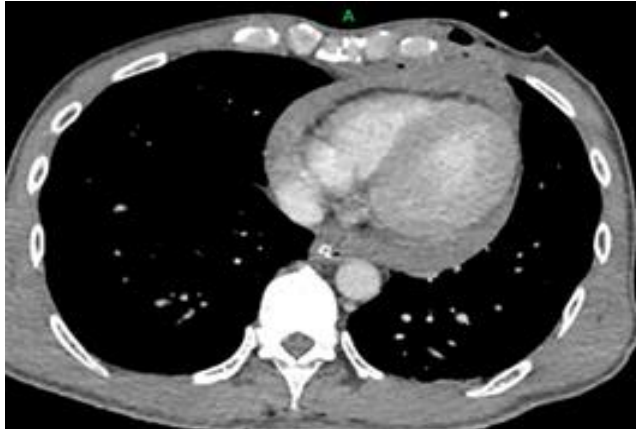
Contrast-enhanced CT of the thorax demonstrates a penetrating anterior chest injury with a clear wound tract extending through the anterior chest wall toward the cardiac silhouette. There is a moderate circumferential hemopericardium, resulting in compression of the cardiac chambers, consistent with acute cardiac tamponade. Focal disruption of the anterior myocardial contour is noted, suspicious for penetrating cardiac injury, most likely involving the right-sided cardiac chambers given their anterior location. Associated anterior mediastinal hematoma is present. No contrast extravasation from the great vessels is identified, and there is no evidence of major thoracic vascular injury. Lung fields are otherwise clear, with no significant pneumothorax or hemothorax.
